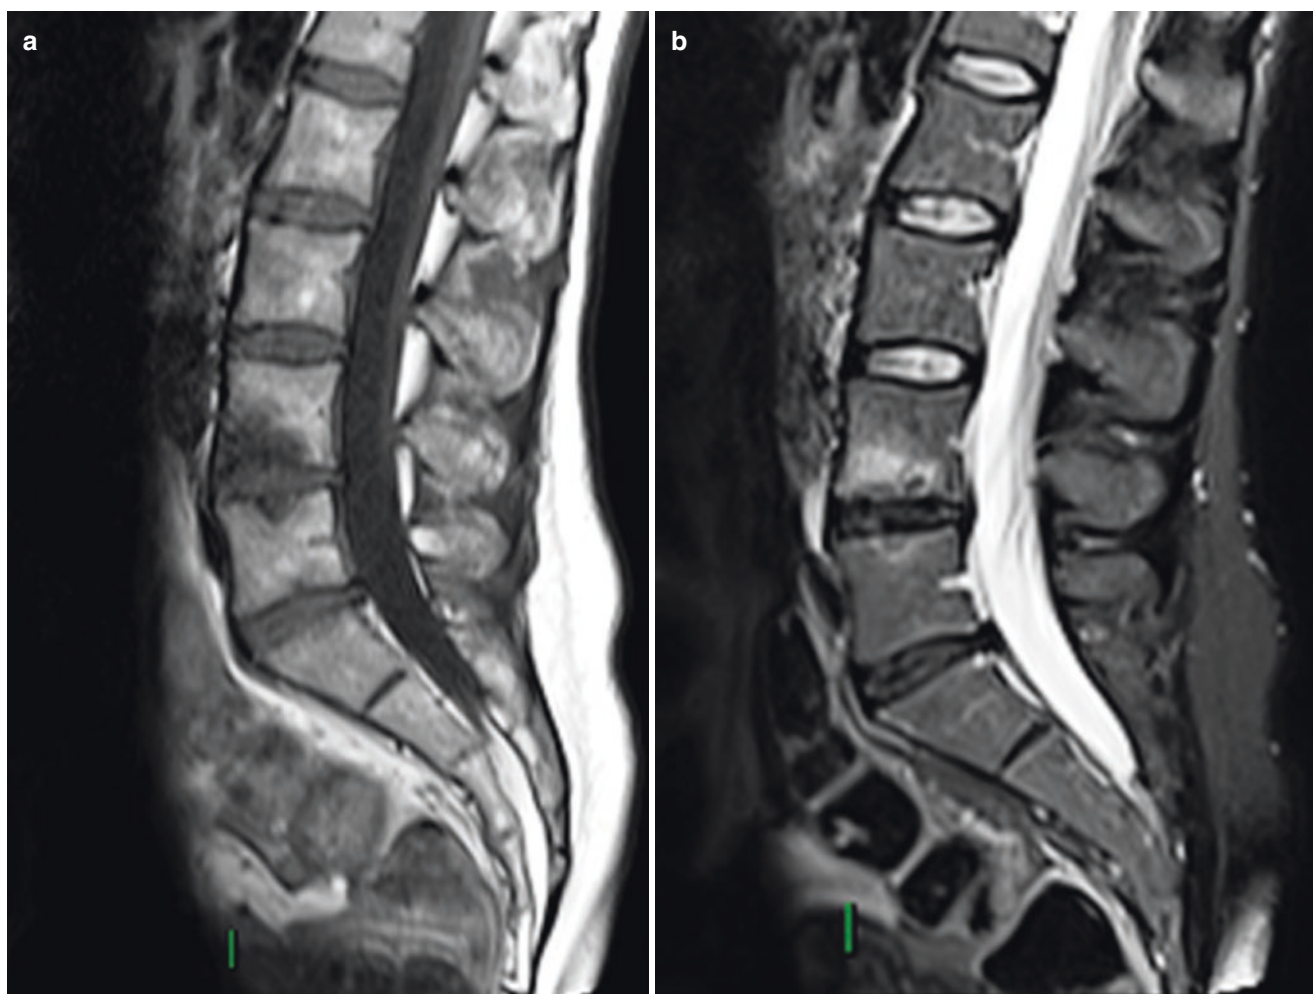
(a) Sagittal T1-weighted MR image demonstrating Andersson lesions at L4–L5 level, with low signal. (b) Sagittal STIR demonstrating BME of Anderson inflammatory spondylitis
